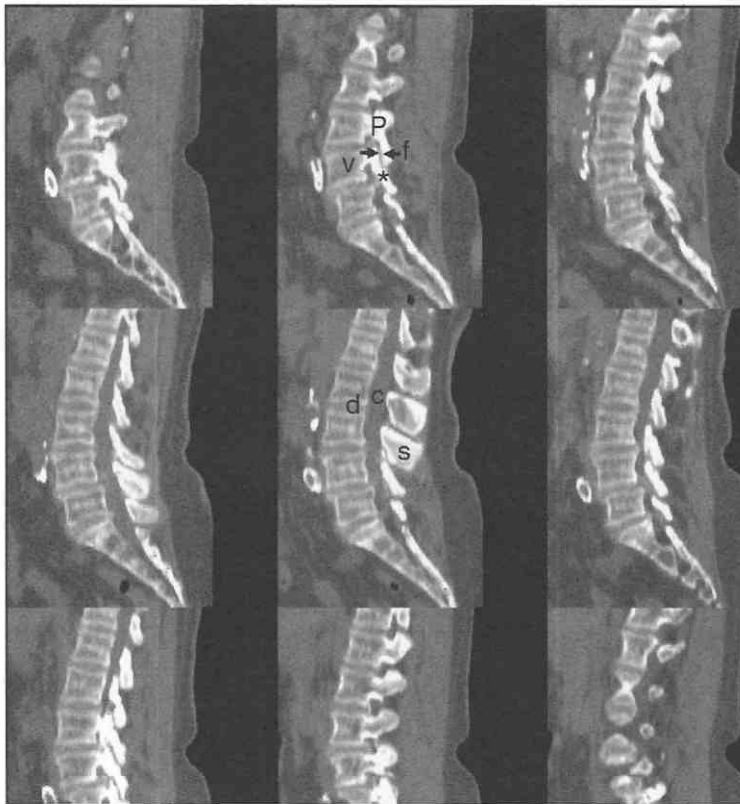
Sagittally reconstructed CT scan. Same patient as in Figure 22-1. The spinal canal (c) as well as the disk (d) is appreciated. Note excellent bone detail, particularly of the pedicle (P), pars interarticularis (asterisk), and facets (f). s, spinous process.
